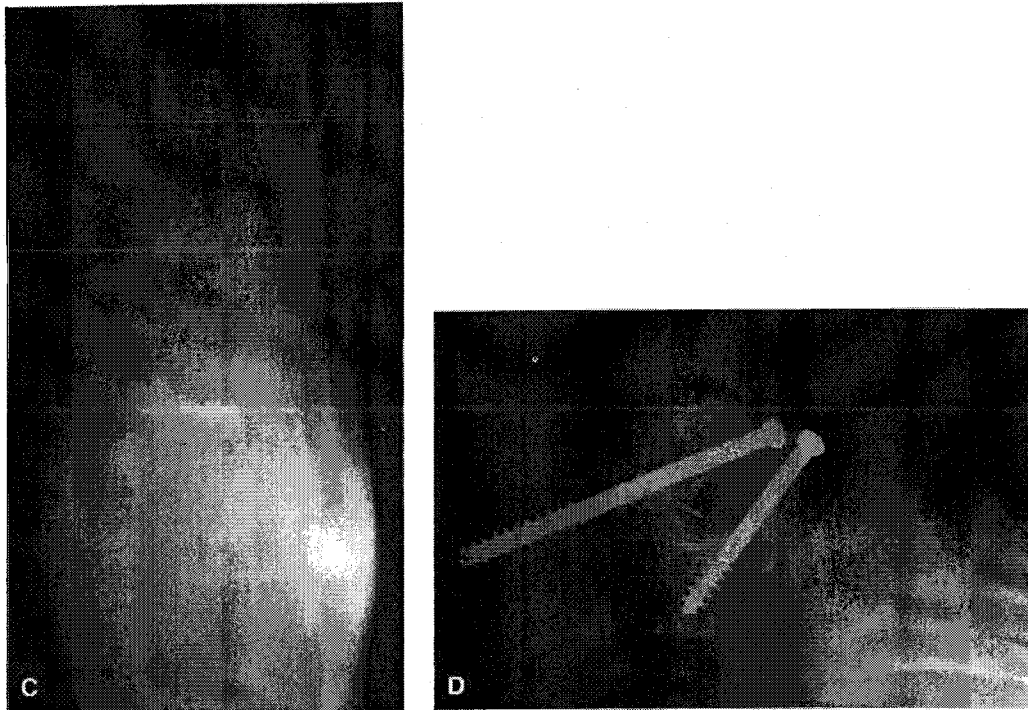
Continued.* Postoperative dorsoplantar (C) and lateral (D) radiographs of the same patient.
